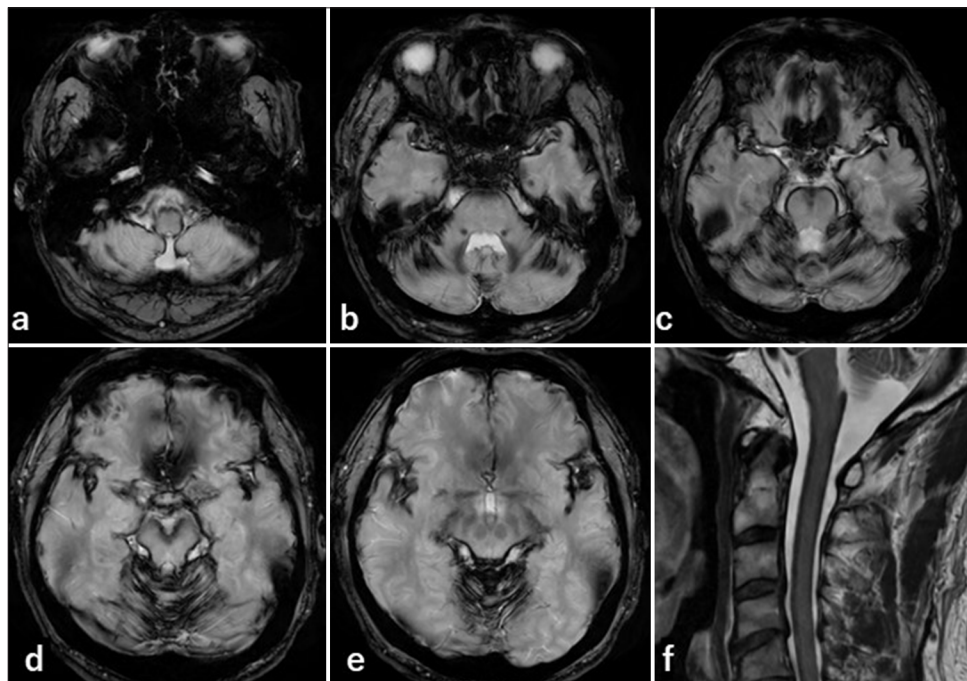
T2*-weighted magnetic resonance imaging of the brain and the upper cervical cord at the presentation. (a–e) It showed low-intensity rims, hemosiderin deposition, on the infratentorial structures including cerebellum and the base of supratentorial structures including the temporal lobes. (f) It also showed hemosiderin deposition on the surface of the upper cervical cord.
